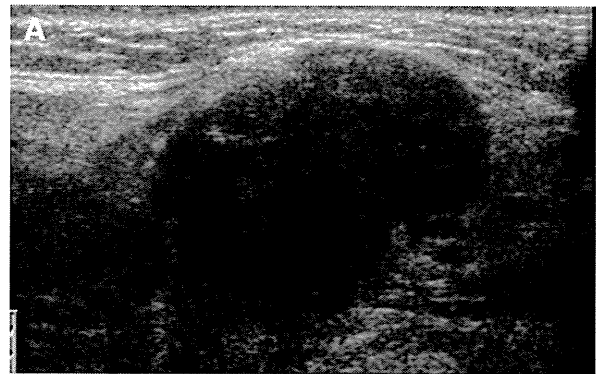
(A) Nodal area in submandibular gland (scanned parallel to the submandibular plane, left: posterior, right: anterior). It is a hypoechoic area bulging from normal surface of the submandibular gland. Note the adjacent submandibular gland parenchyma show normal echo intensity level and homogeneity. (B) Doppler mode of the same case as Fig. 3A. The nodal area shows relatively high vascularization. (C) Nodal areas show a variety in size and in degree of bulge from case to the next. This case shows smaller nodal area than the case seen in Fig. 3A, 3B (scanned same as Fig. 3A).
